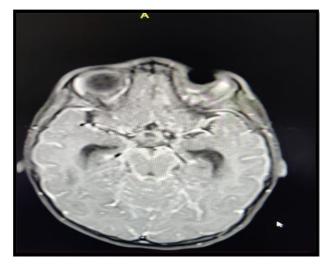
Post contrast MRI brain axial section showing diffuse leptomeningeal enhancement along the basilar cistern enhancement along the basilar cistern
